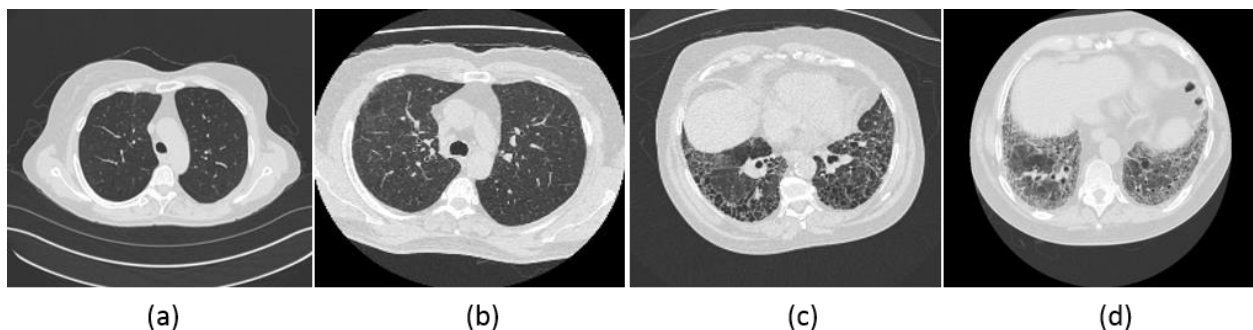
Sample axial slice of chest CT of cases with different lung diseases in our dataset, including (a) emphysema, (b) ground glass, (c) honeycomb, (d) fibrosis
